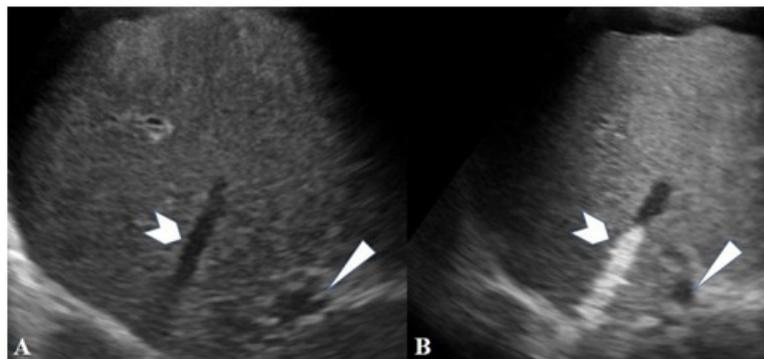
Display of hepatic vein before and after injection of saline on sonogram. (A) Sonogram shows the right portal vein (white triangle) and middle hepatic vein (white arrowhead). (B) As shown as a cloud of echoes by sonogram (white arrowhead), a small amount of agitated saline is injected to confirm IV placement when the catheter is localized in the hepatic vein.
